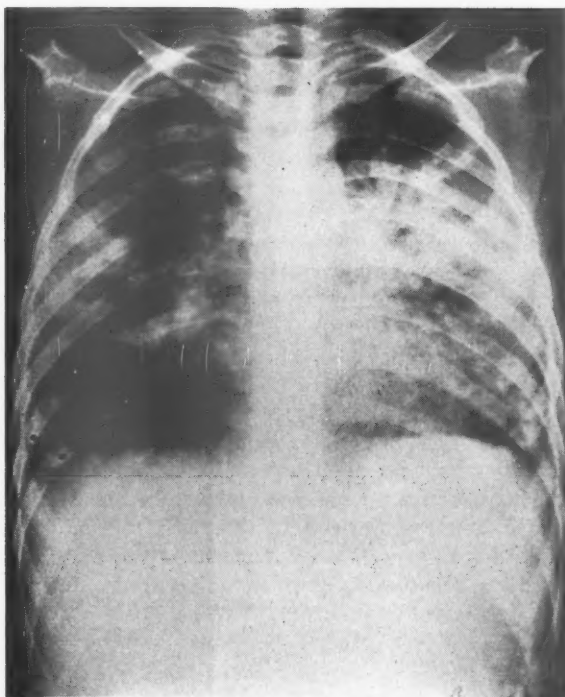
(a).—Antero-posterior radiograph of chest of a girl aged 10 years with staphylococcal pneumonia.
